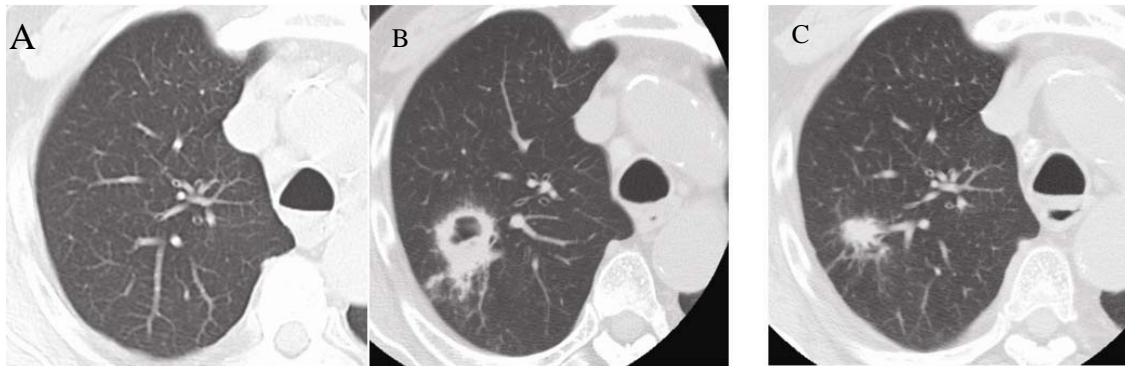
Changes in computed tomography scan data over time. A) Three months before admission; B) on admission (a large cavity with a thick irregular margin, located in the right upper lobe, is evident), C) 3 months after commencement of antibiotic therapy (the cavity has disappeared and only residual scarring is evident).
